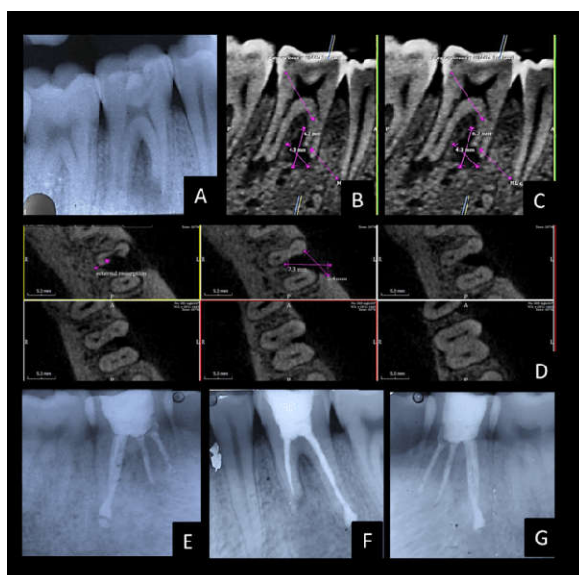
A)IOPA radiograph showed pulpal involvement with caries in #36. B),C) CBCT showed true extent of bone loss vertically in #36. D)CBCT showed true extent of bone loss horizontally in #36. E)After 1 month post-operative IOPA of #36. F)After 3 months post-operative IOPA of #36. G)After 6 months post-operative IOPA of #36
